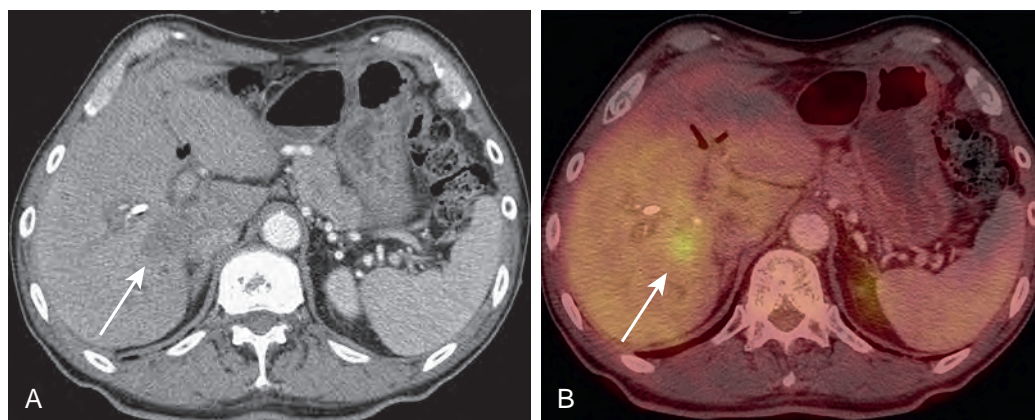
Cholangiocarcinoma. A. Contrast-enhanced CT demonstrates an ill-defined area of low attenuation in the right lobe of the liver (arrow). Note is also made of a biliary stent. B. This area demonstrates increased FDG avidity on PET/CT (arrow). Cholangiocarcinoma was confirmed on biopsy.
